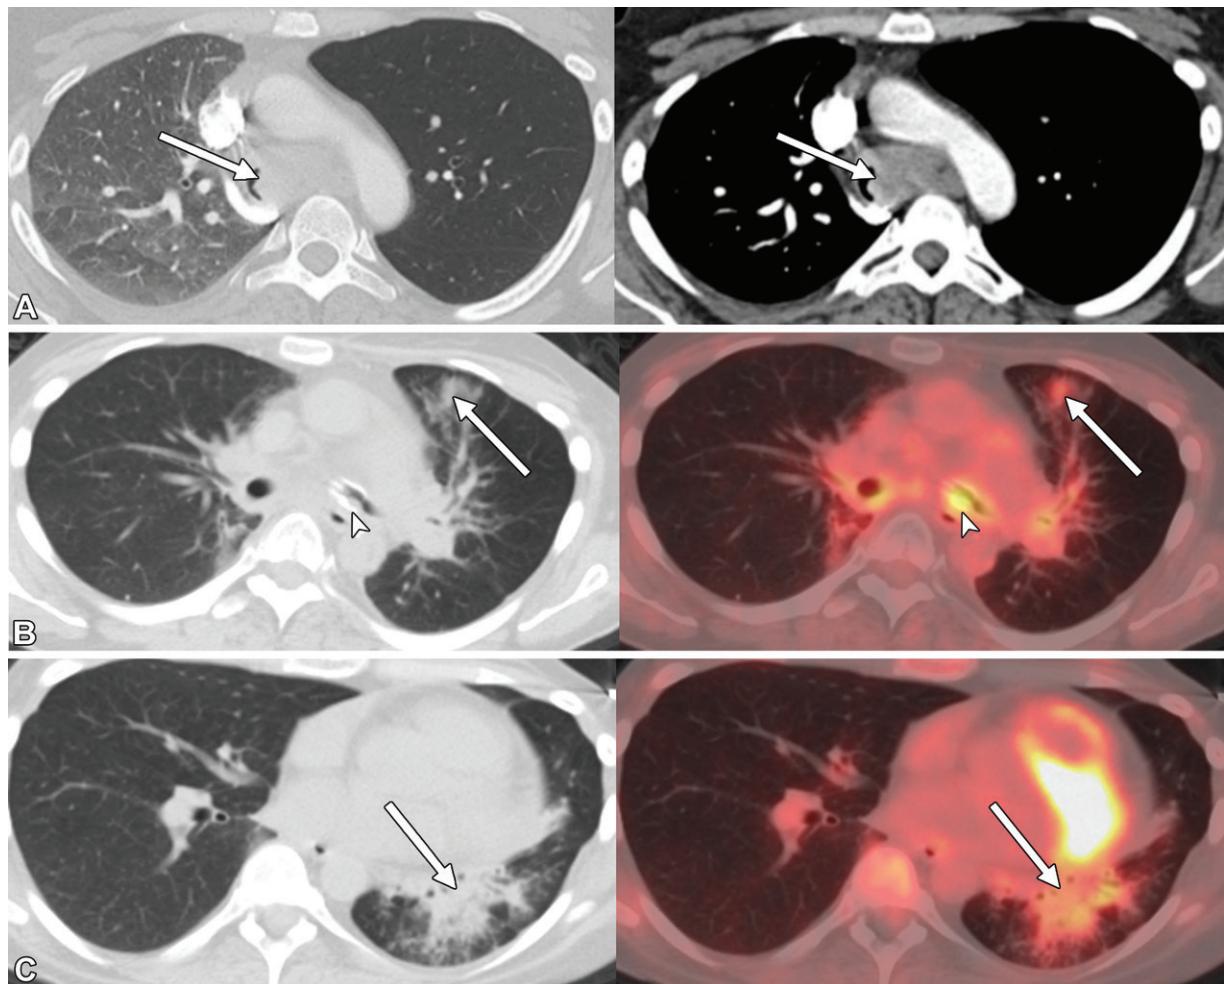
Chemoradiation therapy–associated bronchoesophageal fistula in a 57-year-old woman with adenoid cystic carcinoma of the trachea. (A) Initial transaxial lung-window (left) and soft-tissue-window (right) CT images show the primary tracheal mass (arrows), resulting in stenosis of the right main bronchus and complete occlusion of the left main bronchus with associated right lung atelectasis and left-lung air trapping, respectively. The patient was treated with stent placement in the trachea and left main bronchus followed by chemoradiation therapy. Posttreatment CT images during the next year showed recurrent aspiration with sequelae of chronic aspiration (not shown) that was concerning for esophageal-airway fistula. Esophagram findings confirmed a fistula near the level of the left main bronchus origin (Fig E1). (B, C) Subsequent restaging transaxial CT (left) and fused FDG PET/CT (right) images at the level of the mid thorax (B) and lower thorax (C) show changes of acute-on-chronic aspiration in the left lung with associated mildly hypermetabolic activity, including patchy tree-in-bud nodules and small nodular consolidation in the left lung (arrows in B) with consolidation and volume loss suggestive of scarring predominantly within the left lower lobe (arrows in C). The fistula was not directly visualized with CT. Hypermetabolic activity along the central airways, including the stented left main bronchus (arrowheads in B), most likely represents inflammatory changes related to treatment and aspiration, limiting evaluation for residual or recurrent disease.
